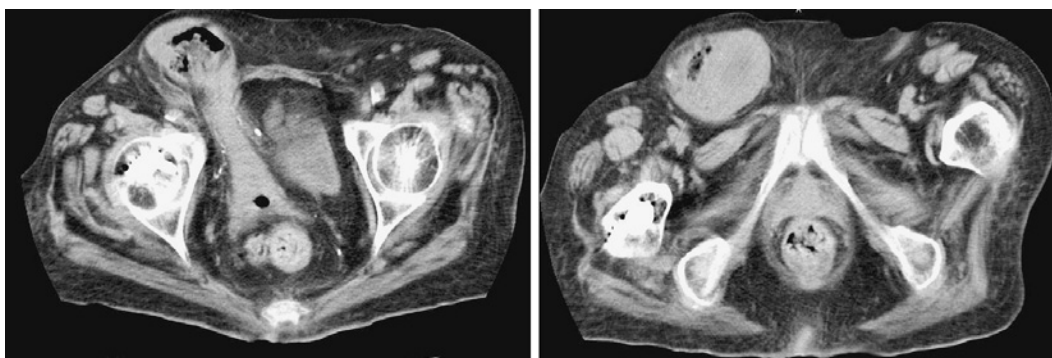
Computed tomography of the abdomen revealed uterine tissue in the right inguinal hernia.
